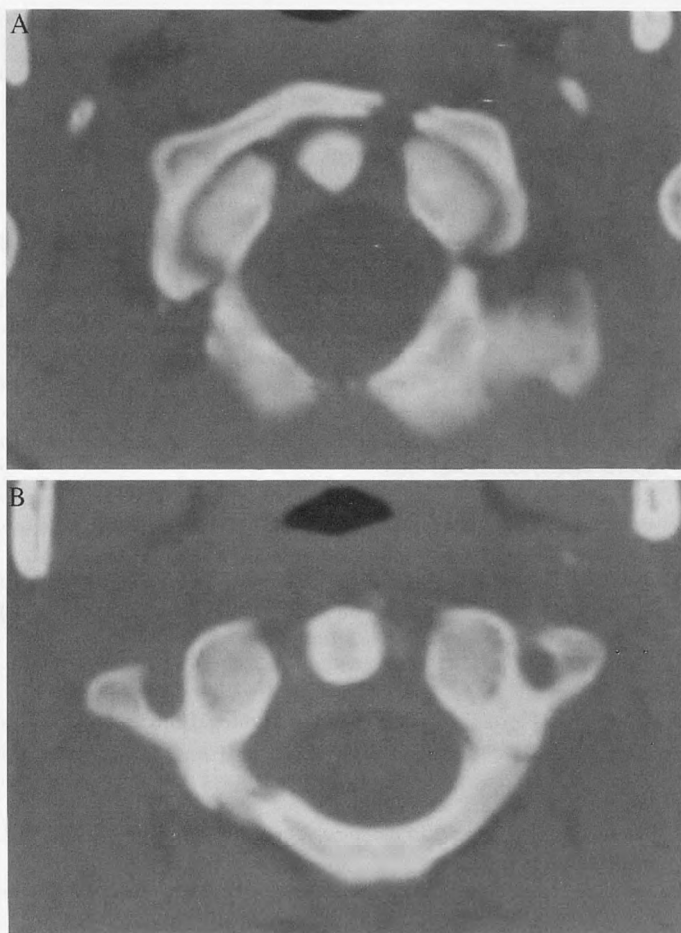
Representative CT scan cuts through the C1 vertebra. Three fracture lines are seen through the ring of C1. (A) A mildly displaced fracture through the left anterior arch of C1 is best appreciated on this cut. (B) Minimally displaced fractures through the posterior arch of C1 are seen on this cut, one adjacent to the left lateral mass and the second involving the right posterior arch.
